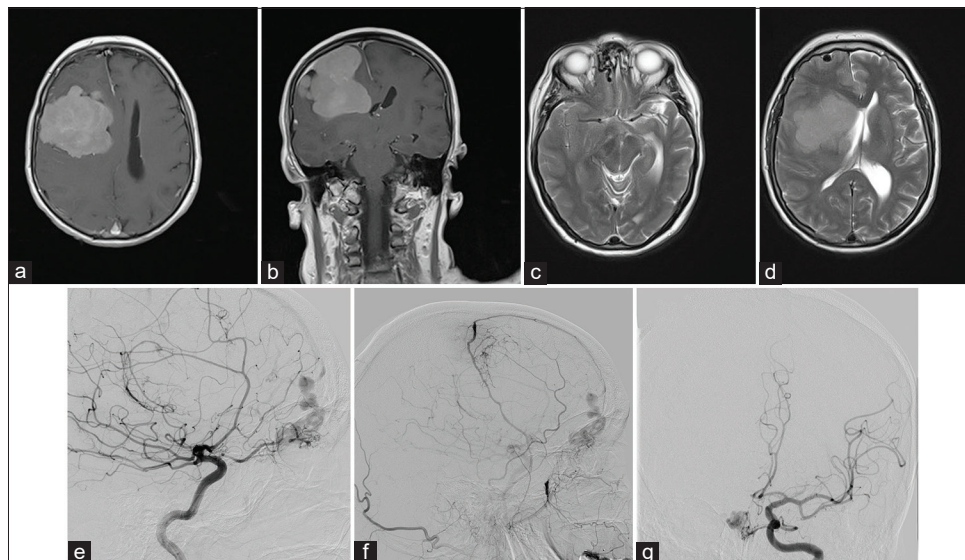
A 74-year-old patient presented with left-sided weakness. Postcontrast T1-weighted magnetic resonance images (a and b) showed a large right convexity meningioma. Signal voids were also noted in the right anterior cranial fossa, without direct continuity with the meningioma (c and d). DSA showed a right anterior cranial fossa dural arteriovenous fistula (DAVF) (e-g) supplied by right ethmoidal arteries from bilateral ophthalmic arteries, right distal internal maxillary artery, and hypertrophied right anterior meningeal artery. The DAVF drained into the super sagittal sinus and vein of Trolard.
